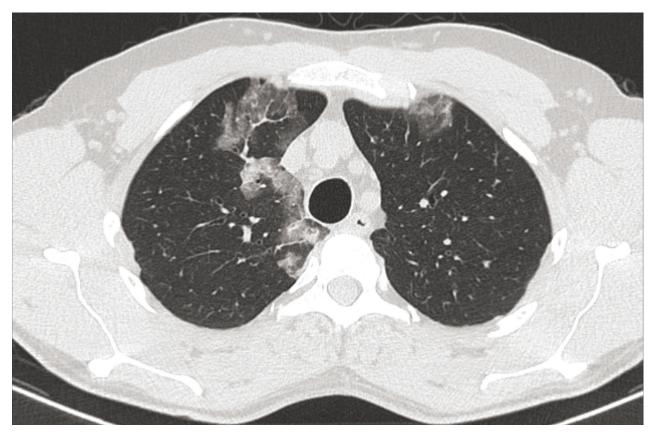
Computed tomography scan showing pulmonary infiltrates in an EGPA patient. (courtesy of Xavier Puéchal).
